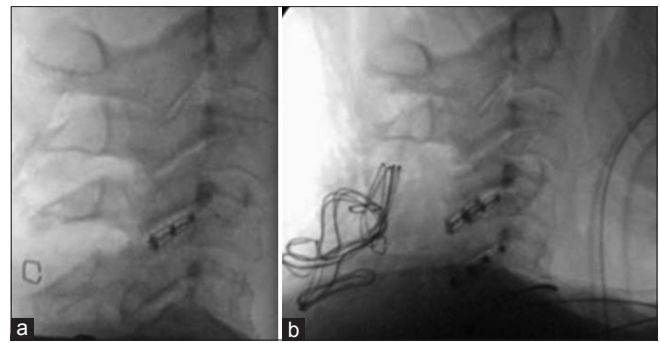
Lateral X-rays obtained intraoperatively demonstrate no change in cervical lordosis before (a) and after (b) placement of C5–C6 cage. The biggest determinant of postoperative alignment is cervical lordosis obtained in the Mayfield on the operative table
